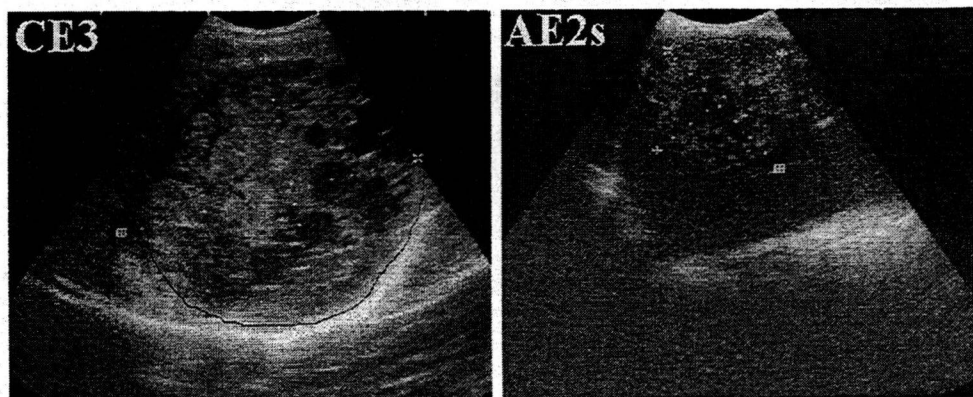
Hepatic ultrasound images of the patient with dual infection (both CE and AE) in northwest Sichuan Province. CE and AE lesions were marked by a circle, respectively.
